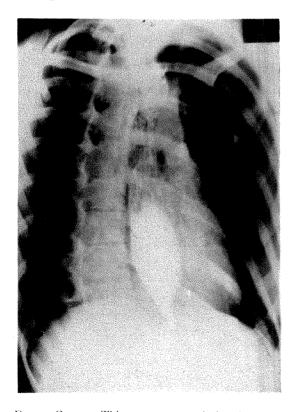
Case II. This case presented the characteristic findings of achalasia of the cardia and was so diagnosed roentgenologically. Esophagoscopic examination revealed an organic stenosis of the lower end of the esophagus and at operation this was found to be due to an extensive malignancy.
